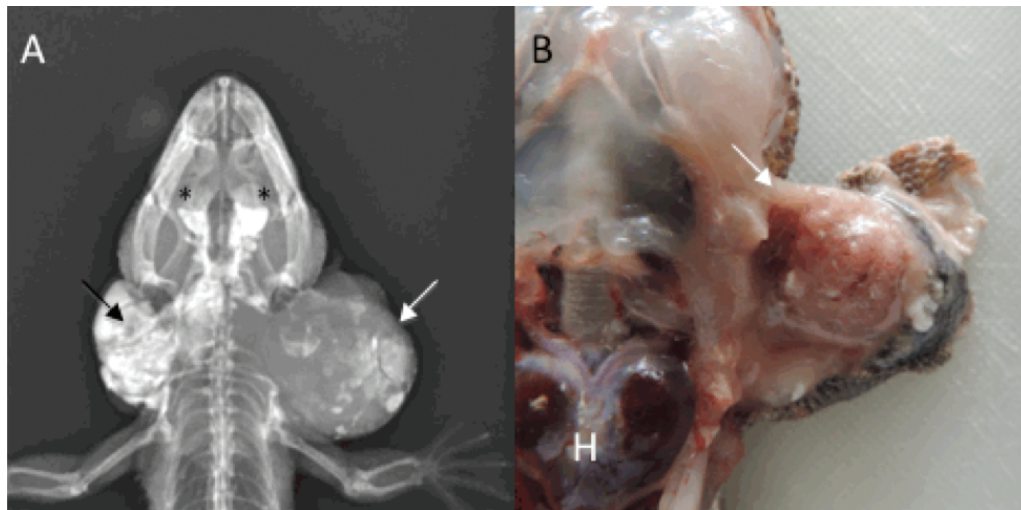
Dorsoventral radiographic image (A) and postmortem photograph (B) of the left endolymphatic sac (white arrows). (A) An eccentric, partially mineralized, soft tissue opacity mass effect is present in the left cervical region (white arrow). A diffuse mineral opacity is also present in the right endolymphatic sac (black arrow) and left and right inner ears (*). (B) A firm, pedunculated, tan mass expanded the lumen of the sac (white arrow). For reference, the heart (H) is positioned at the bottom left corner of this photograph. Bar = 1 cm.
